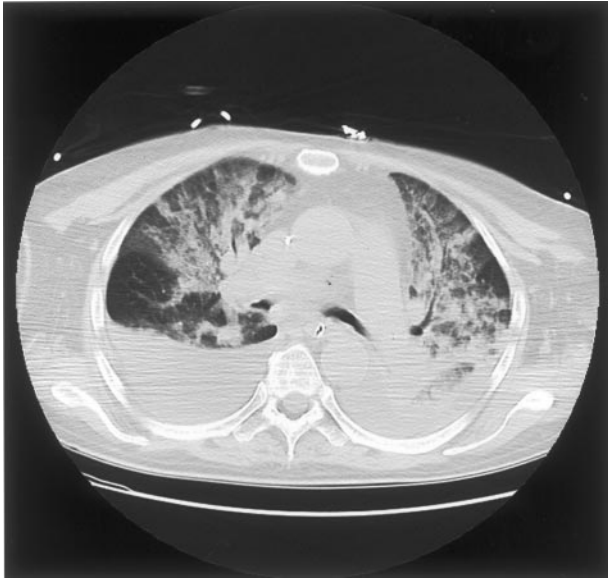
Chest CT scan demonstrating the bilateral alveolar infiltrates and small-to-moderate pleural effusions.
